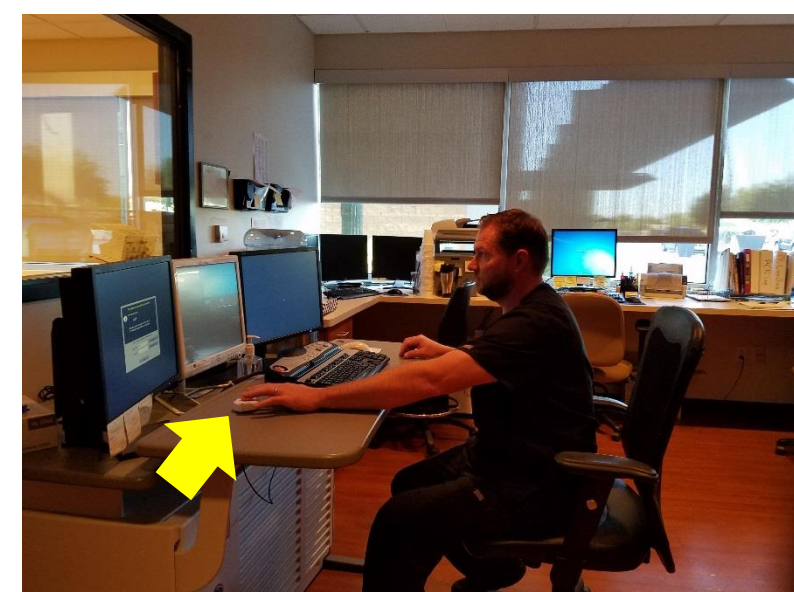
Intercom (arrow) readily accessible for CT technologists
